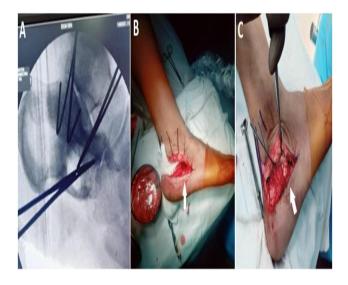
(A-C): Intra-operative radiograph depicting the lesion in the anterior process of calcaneus; bone defect post curettage (arrow) and defect filled with synthetic bone graft (arrow) and covered by the gel foam.
